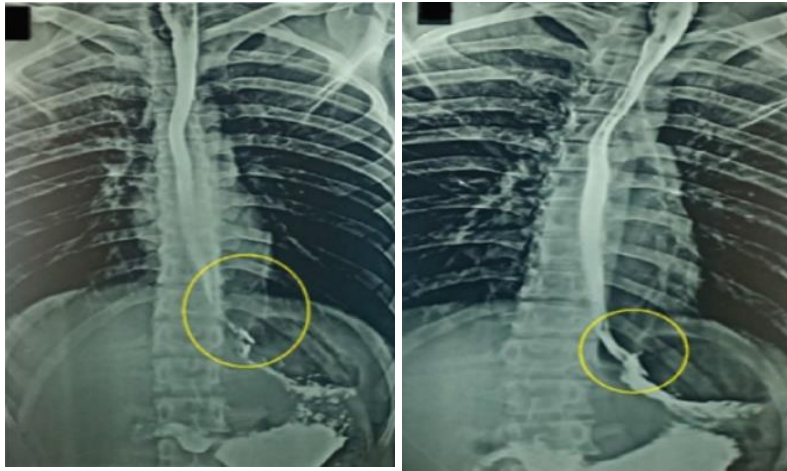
Barium swallow X-rays: PA view, contraction at the lower esophageal region (31/07/23).
